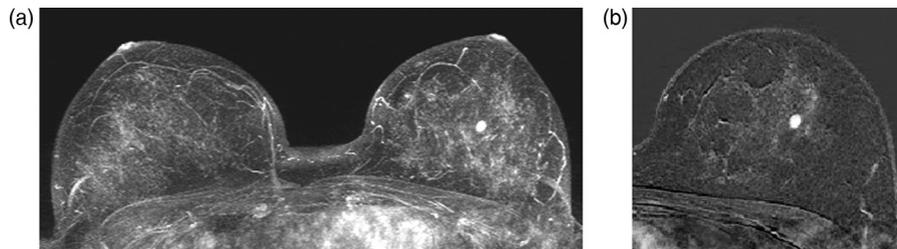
Fibroadenoma. MRI of the breast. MIP technique (a) and the single slice subtraction image of the left breast (b) show an oval mass with well-defined borders and homogeneous uptake of the contrast material
